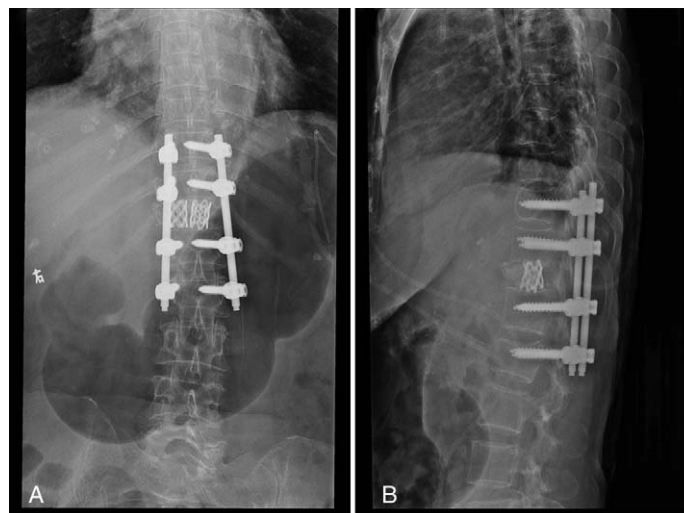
(A and B) Immediately postoperation. CT images exhibited successful decompression and reconstruction of the collapsed vertebral body using titanium mesh bone grafting combined with pedicle screw internal fixation. CT=computed tomography.
